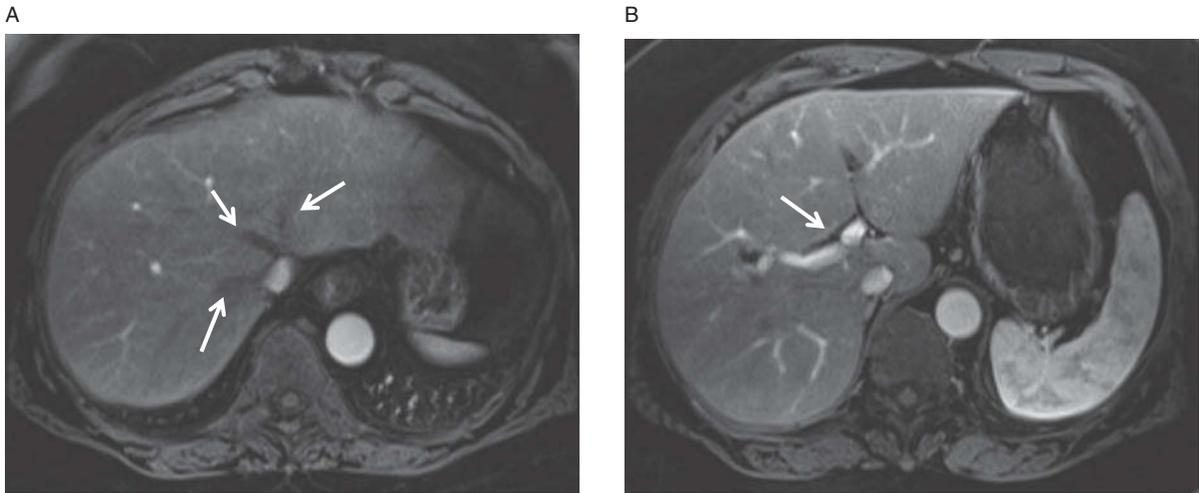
Axial T1-weighted post-contrast arterial phase images demonstrate lack of contrast enhancement of the hepatic veins (arrows A) with some enhancement of the portal vein (arrow B). Note also the heterogeneous enhancement of the spleen which is typical of an arterial phase image.
